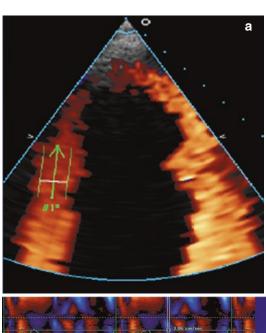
Apical four-chamber projection demonstrating the Pulsed Wave sample volume positioned at the lateral corner of the mitral annulus (arrow)
